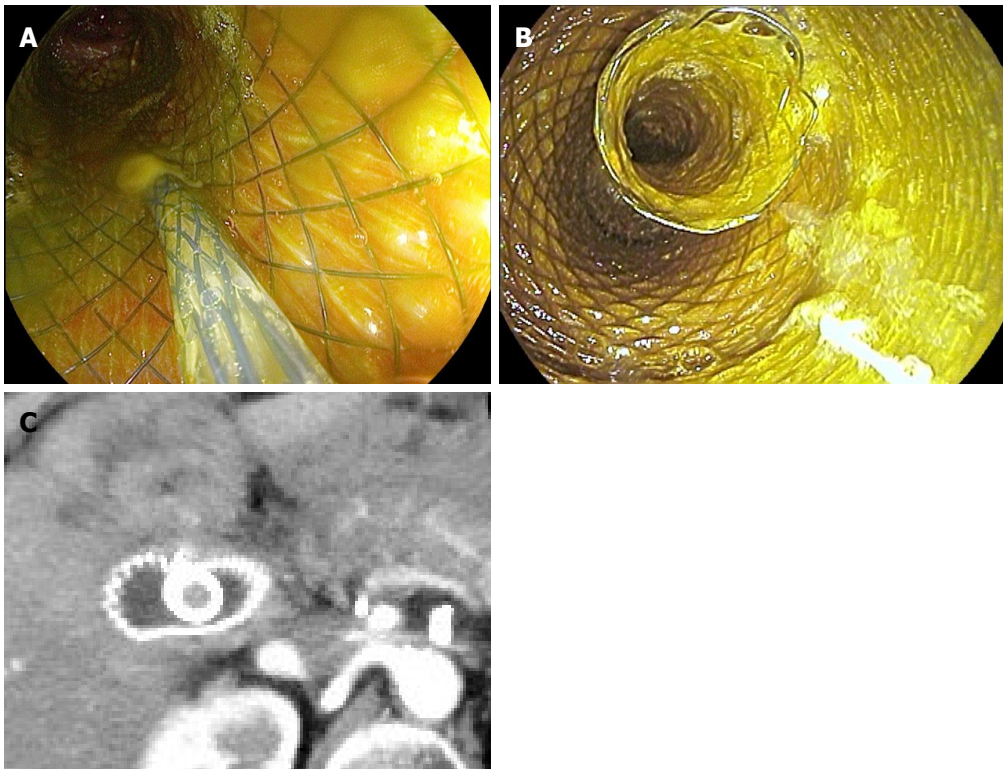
Bilio-enteric external fistula after pancreaticoduodenectomy. A: An 8 mm × 4 cm biliary SEMS was inserted into the common bile duct through the meshes of the enteral SEMS; B: Final stent complex at the end of the procedure; C: Detail of CT scan performed two days after the intervention showing the relationship between the two SEMS (biliary stent protruding inside the enteral).
